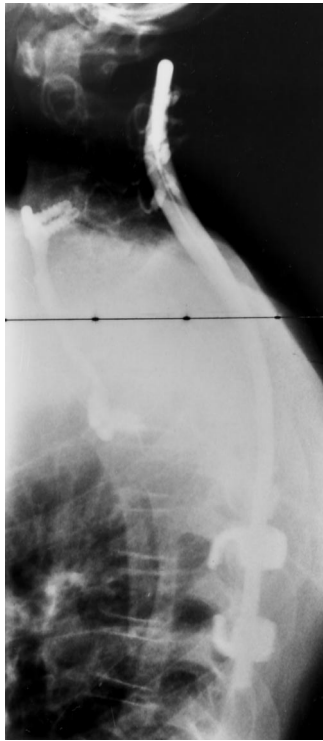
Case 2. Postoperative lateral radiograph of the cervicothoracic spine. Note correction of sagittal alignment with anterior fixation from C4 to T4 and posterior instrumentation from C2 to T7.
